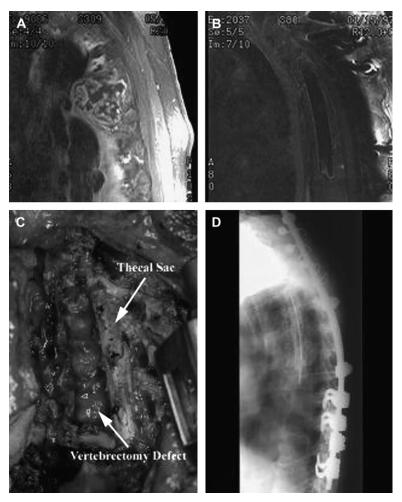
(A) Preoperative T1-weighted with gadolinium MRI showing a heterogeneously enhancing chondrosarcoma of the thoracic spine. (B) Postoperative MRI following 3-level vertebrectomy. (C) Intraoperative photo of 3-level vertebrectomy from the anterior approach. (D) Lateral radiograph of instrumented construct with methylmethacrylate and posterior fixation. (From York JE, Berk RH, Fuller GN, et al. Chondrosarcoma of the spine: 1954 to 1997. J Neurosurg Spine 1999;90(1):73–8; with permission.)
